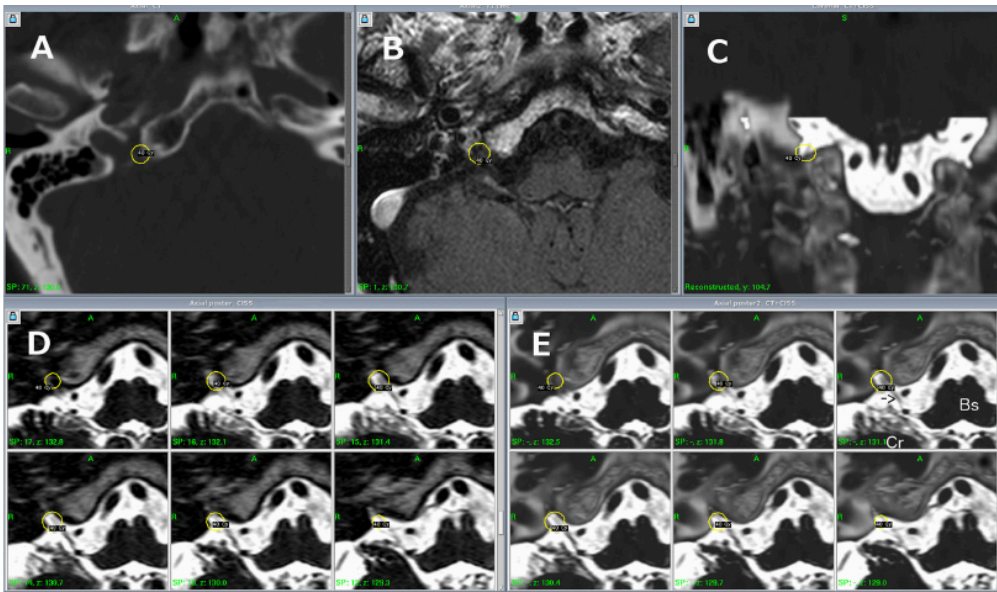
GKRS treatment planning. Axial bone-windowed CT image showing the glossopharyngeal meatus (a). T1-weighted contrast enhanced MRI acquisition (b). Coronal three-dimensional constructive interference in steady-state (CISS) MRI merged with bone-windowed CT acquisition, showing the glossopharyngeal meatus (c). Axial CISS MRI, showing the treatment planning and the relevant dosimetry to the nerve (d). Axial CISS MRI merged with bone-windowed CT scan showing the relevant anatomy and the neurovascular conflict (black arrow) (e). Bs brainstem, Cr cerebellum
